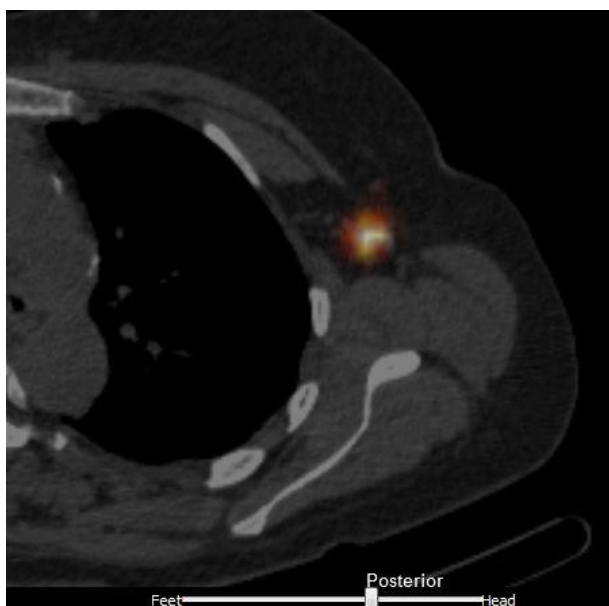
Hybrid SPECT/CT imaging visualizing a radioactive SLN in the left axilla of a study patient (transaxial projection).
